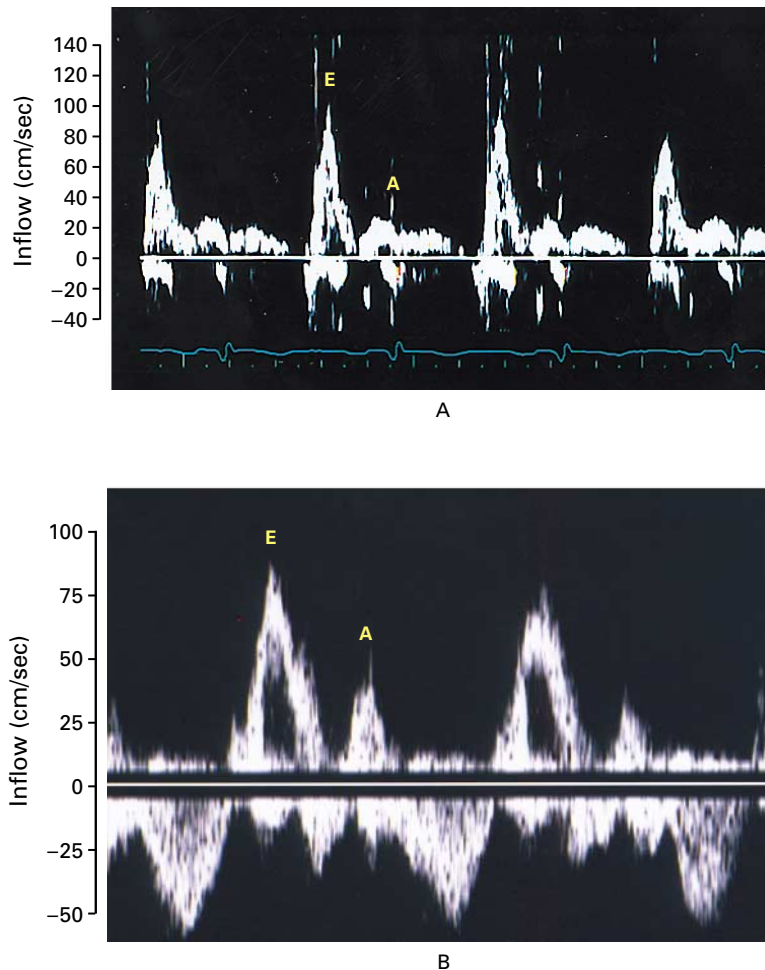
Doppler Patterns of Left Ventricular Inflow in a Patient with Restrictive Cardiomyopathy Due to Cardiac Amyloidosis (Panel A) and a Normal Subject without Cardiac Disease (Panel B). The ratio of early-diastolic filling (E) to atrial filling (A) is higher in the patient with restrictive cardiomyopathy. (Figure courtesy of Dr. Martin Goldman.)
